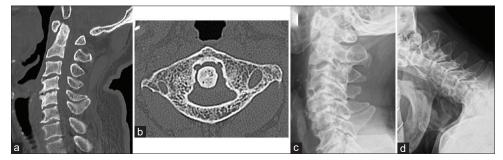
Preoperative mid-sagittal and axial image of computed tomography (a and b) demonstrating a hypoplastic but intact posterior arch of the atlas. Flexion (c) and extension (d) cervical laretal radiograph revealed no atlantoaxial instability.
